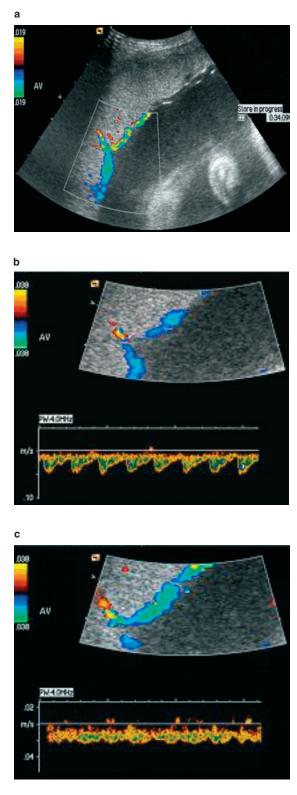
Two-dimensional color Doppler appearances of an arteriovenous (AV) anastomosis. (a) A blood vessel is seen to enter the chorionic plate and a vessel emerge from the same cotyledon to continue towards the contralateral twin. Doppler waveforms confirm the pulsatile arterial (b) and non-pulsatile venous (c) components of the AV anastomosis²⁵
